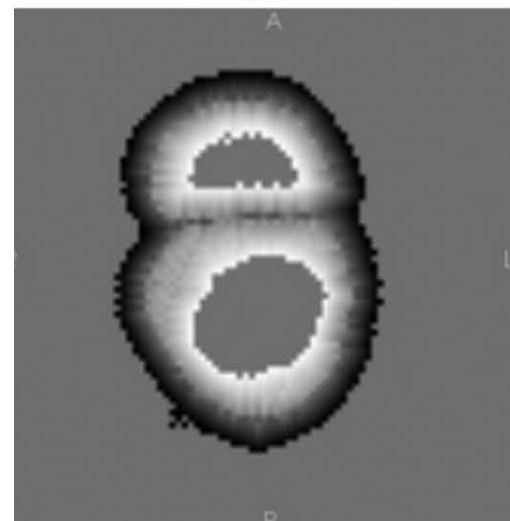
Narrow band-based image registration procedure. A two-step registration is employed here to successively deal with translational and deformation miss-matches. (CT = computed tomography; MRI = magnetic resonance imaging.)
